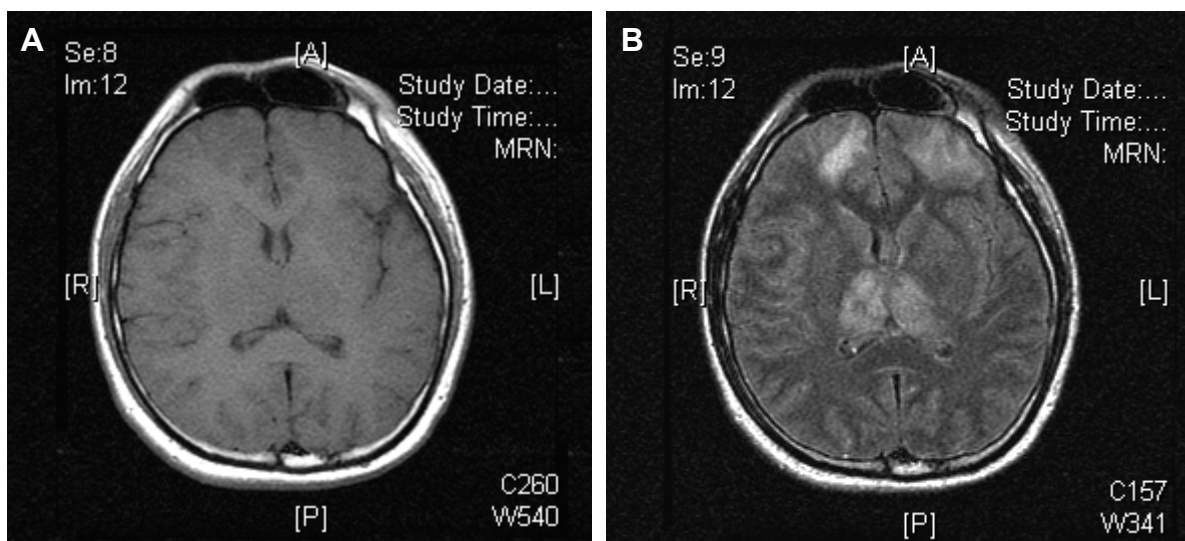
Brain magnetic resonance imaging showing (A) symmetrical faint hypointensity on T1WI and (B) hyperintensity on FLAIR in bilateral thalami, suggestive of Japanese encephalitis.
